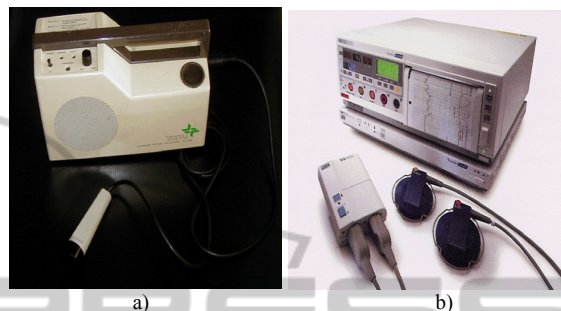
Traditional methods for Fetal heart rate measurements: auscultation, Doppler ultrasound (a), and cardiotocography (b).
